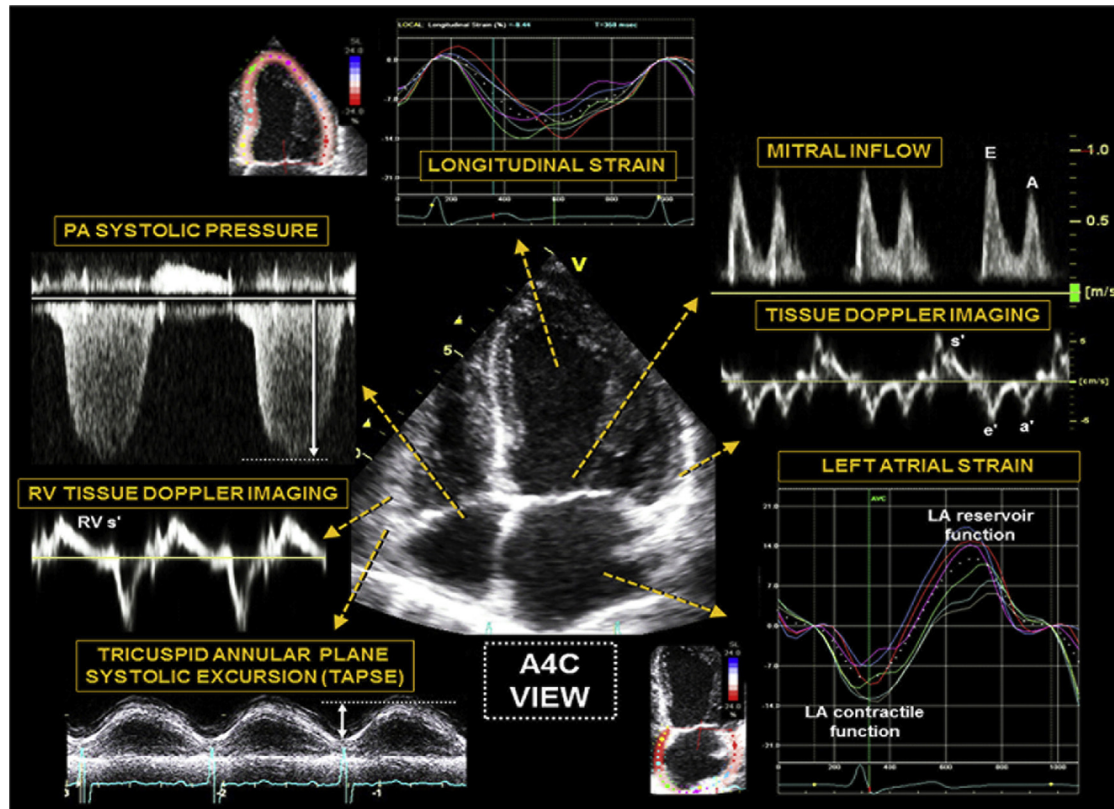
Comprehensive Echocardiographic Phenotypic Analysis of Heart Failure With Preserved Ejection Fraction
